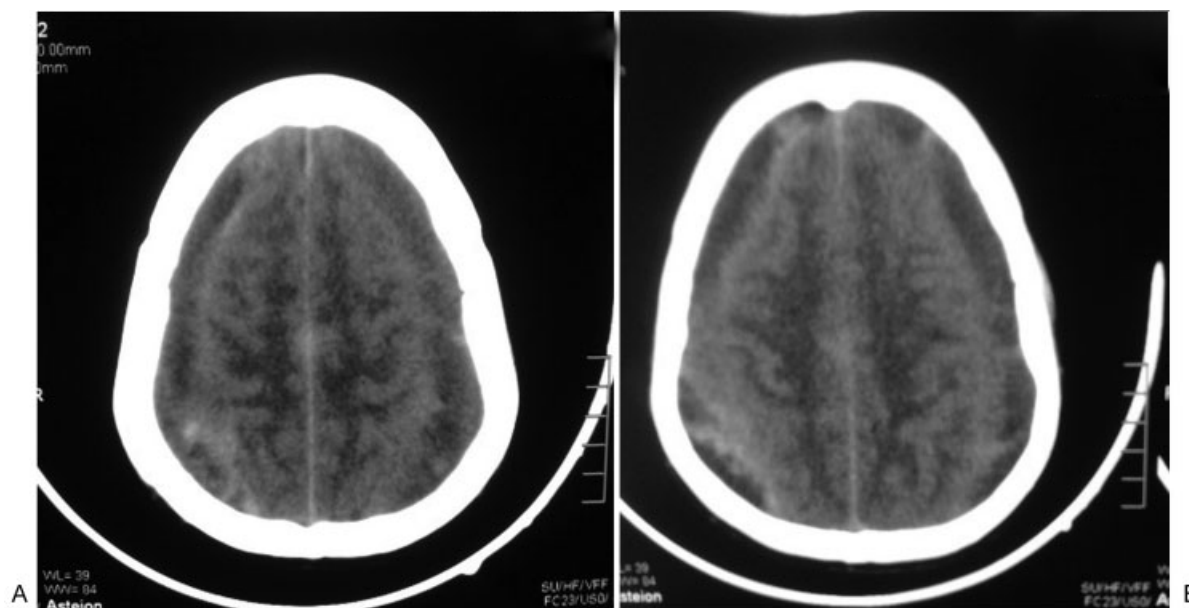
Preoperative CT of brain (A, B); preoperative MRI (C–E); postoperative CT (F, G); postoperative MRI (H); postoperative MRI: DWI (I); MRA (J); MRV (K, L). A–D showing bilateral frontotemporoparietal chronic SDH without midline shift. E–G showing postcraniotomy status with minimal residual chronic subdural without any midline shift. H postoperative MRI DWI showing bilateral PCA territory infarction; with normal MRA (I) and MRV (J and K).
